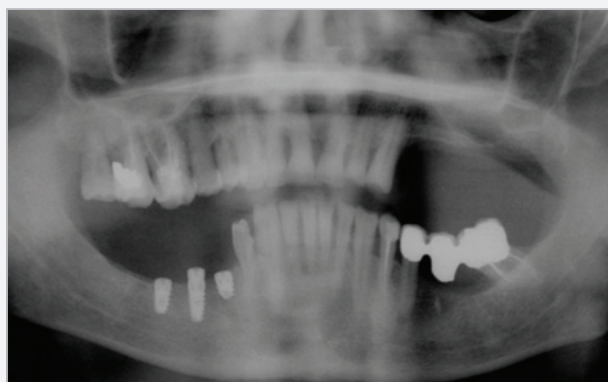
Case 1 - Postoperative x-ray with the 4,2 6mm Seven implant in position.
